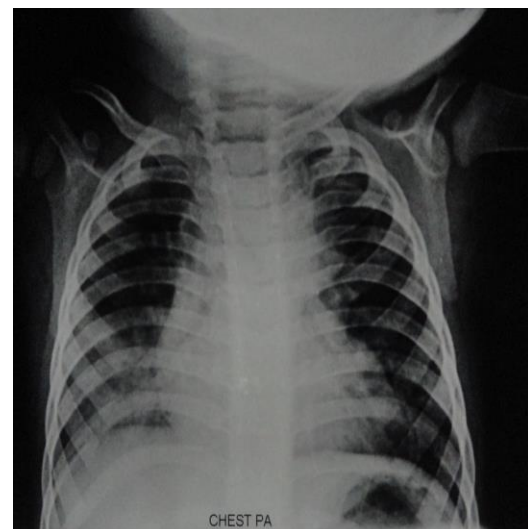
Follow up Chest x-ray (PA view) after 8 weeks of ATD therapy showing resolution of consolidation and cavity
